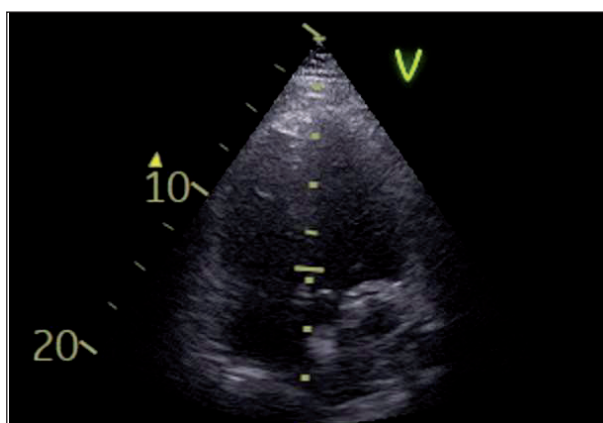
Transthoracic echocardiography in five-chamber apical view showing “RAC sign”, a binary structure above the mitral valve plane into the atrioventricular groove overlapping the aortic root.
